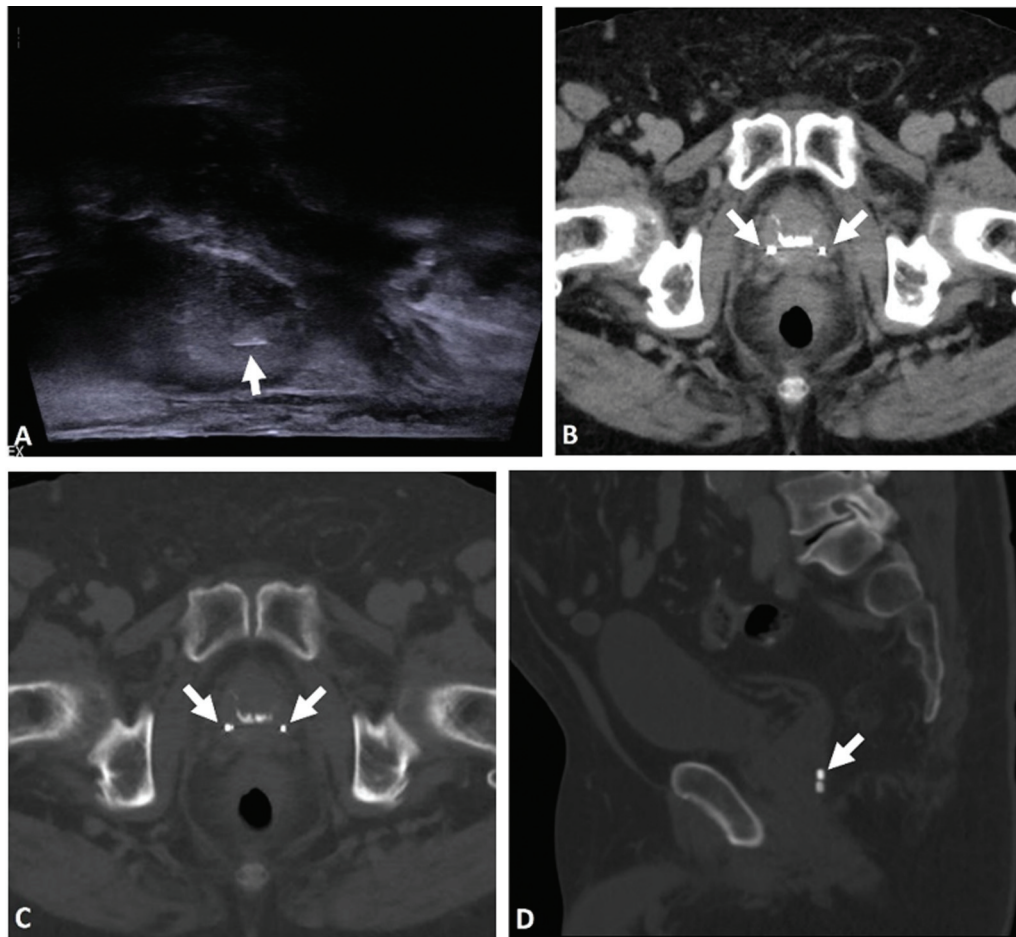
Fiducial markers. Transrectal ultrasound in sagittal view showing a fiducial marker (*arrow*) in the prostate apex after insertion via the transperineal route. FM (*arrows*) seen on (B) soft tissue and bone windows (C: axial image; D: sagittal reformation) of contrast-enhanced computed tomography (CT) appearing as metallic densities in the prostate gland.
